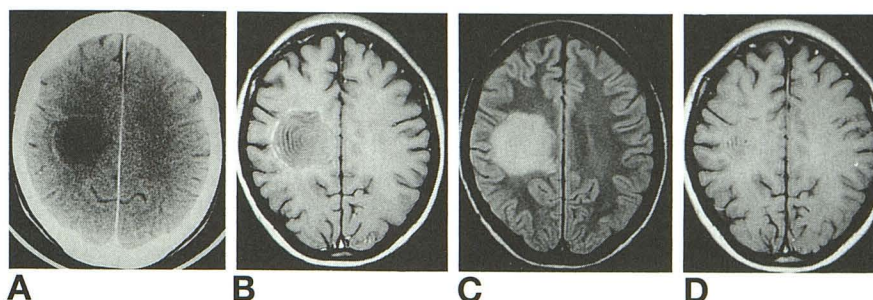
A, Postcontrast CT performed 2 weeks after the onset of the left hemiparesis shows a large hypodense lesion with rim enhancement in the right parietal lobe.
